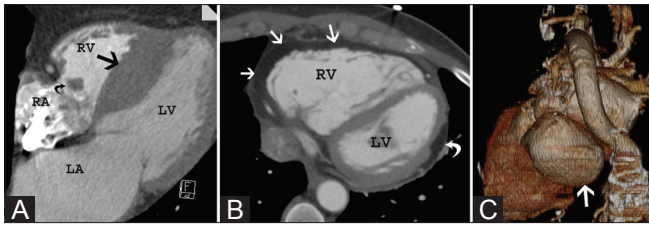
(A–C): Cardiomyopathy. Axial CT image (A) shows asymmetric hypertrophy of the inter-ventricular septum (straight arrow) in a patient with hypertrophic cardiomyopathy. There is also an incidental tricuspid valve fibroelastoma (curved arrow). Axial CT image (B) in a patient who presented with arrhythmia shows diffuse fatty infiltration of the right ventricular myocardium (straight arrows) and dilation of the right ventricle, consistent with arrhythmogenic right ventricular dysplasia (ARVD). There is also focal fatty infiltration of the left ventricle (curved arrow). 3D volume-rendered CT image (C) shows a large pseudoaneurysm (arrow) arising from the base of the left ventricle
